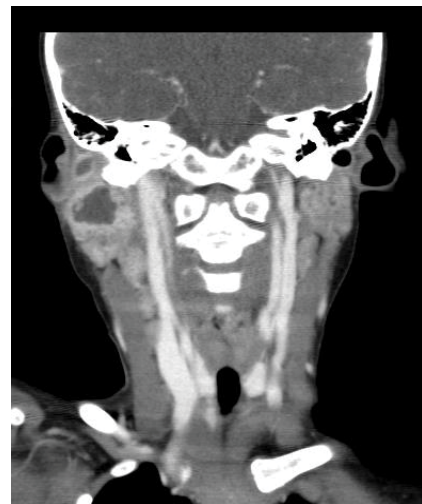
Computed tomography scan with contrast demonstrating a bi-lobed right type II first branchial cleft anomaly.
